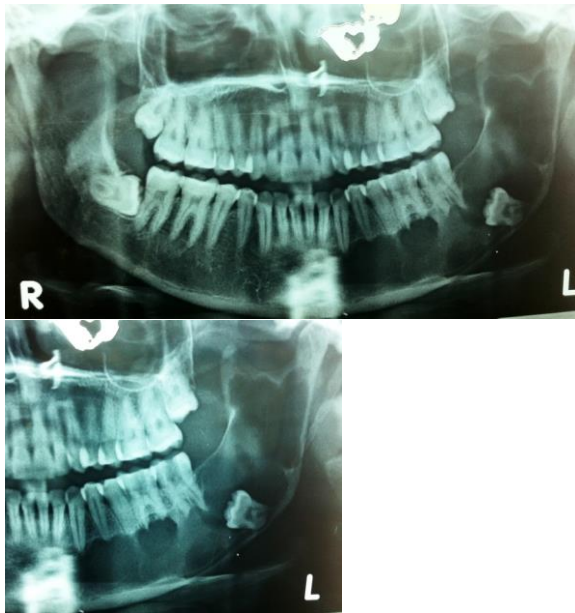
Orthopantomogram reveals an unilocular and scalloped borders in left mandibular region extending in relation from lateral incisor to the sigmoid notch involving body and ramus associated with impacted 38 and pathological resorption of 35, 36, 37.
